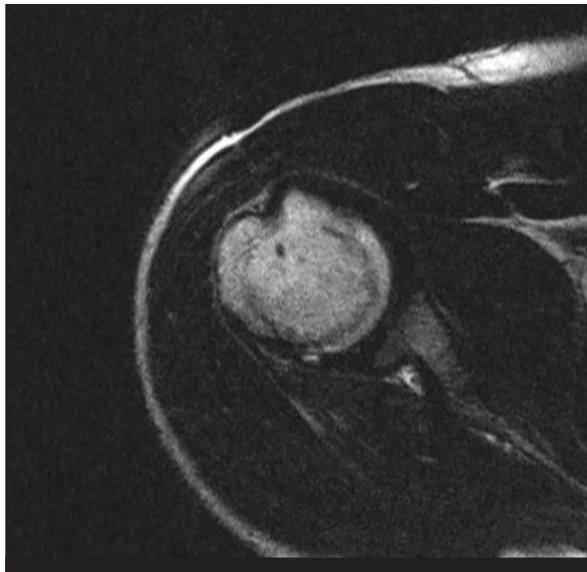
T1-weighted axial MRI depicting the tumour
